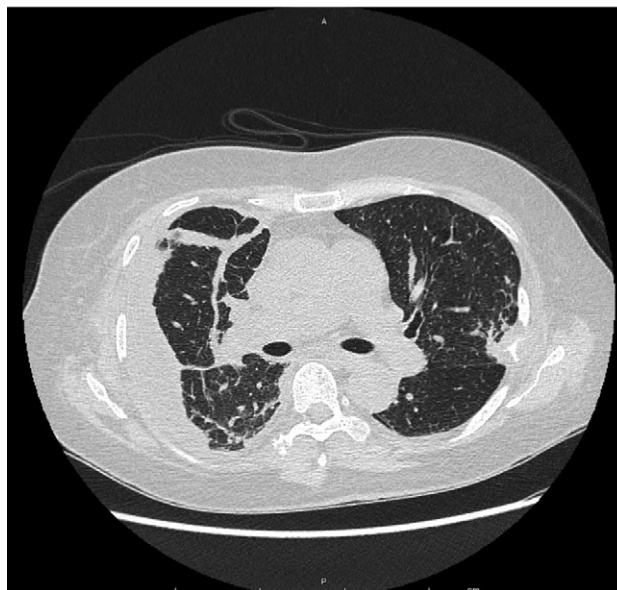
non-contrast CT performed in November 2015 showed new unilateral pleural effusion, bilateral progressing pulmonary nodules and pleural irregularity and thickening initially thought to be consistent with lung malignancy.
